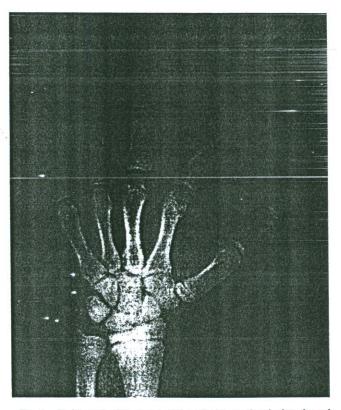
Radiograph of the hand of Twin B showing brachydactyly and clinodactyly.
